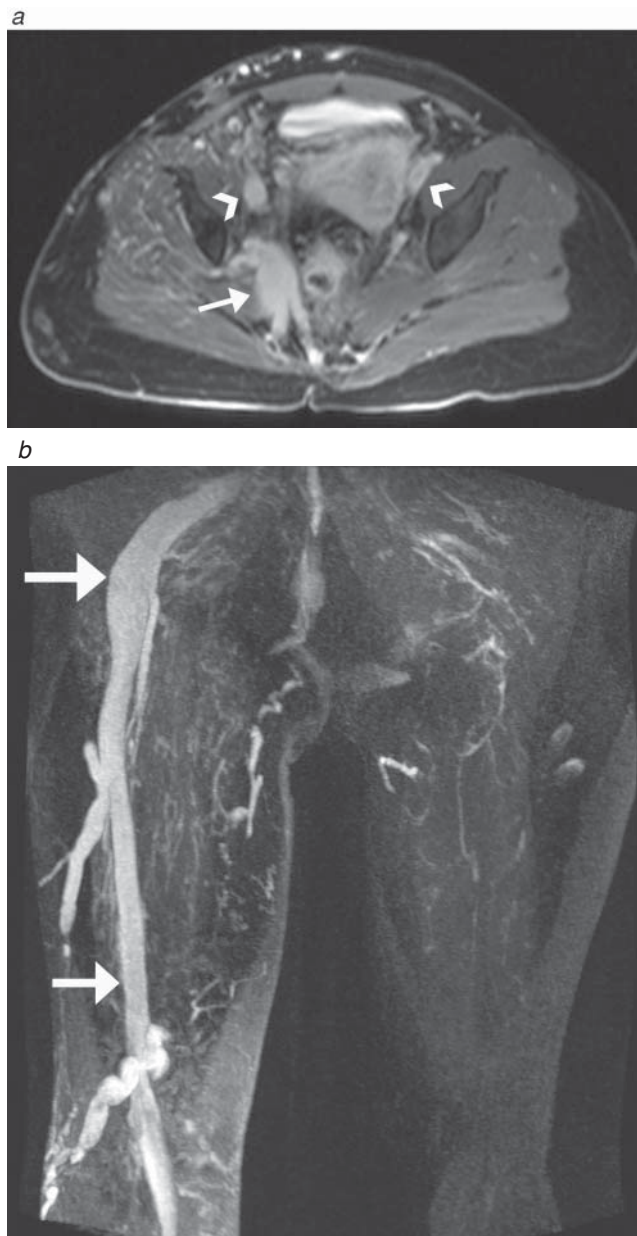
A 29-year-old female presented with a swollen right lower limb. (a) Axial contrast-enhanced fat saturation T₁-weighted magnetic resonance image through the pelvis, acquired in the venous phase, demonstrating an enlarged enhancing venous structure posterior within the right pelvis consistent with a congenital anatomic variant of a persistent sciatic vein (arrow). Note the presence of both iliac venous systems (arrowheads). (b) Coronal maximum-intensity projection from the time-resolved magnetic resonance venogram demonstrating the right persistent sciatic vein (arrow).
